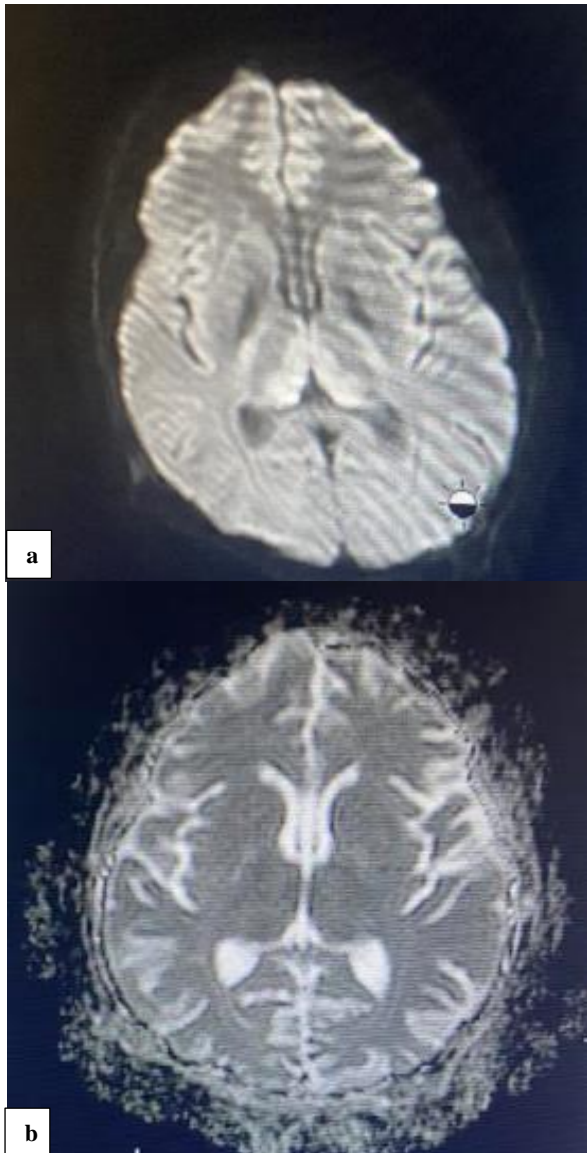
(a and b): Hyperintense signal on T2 and FLAIR with diffusion restrictions in bilateral thalamus.
